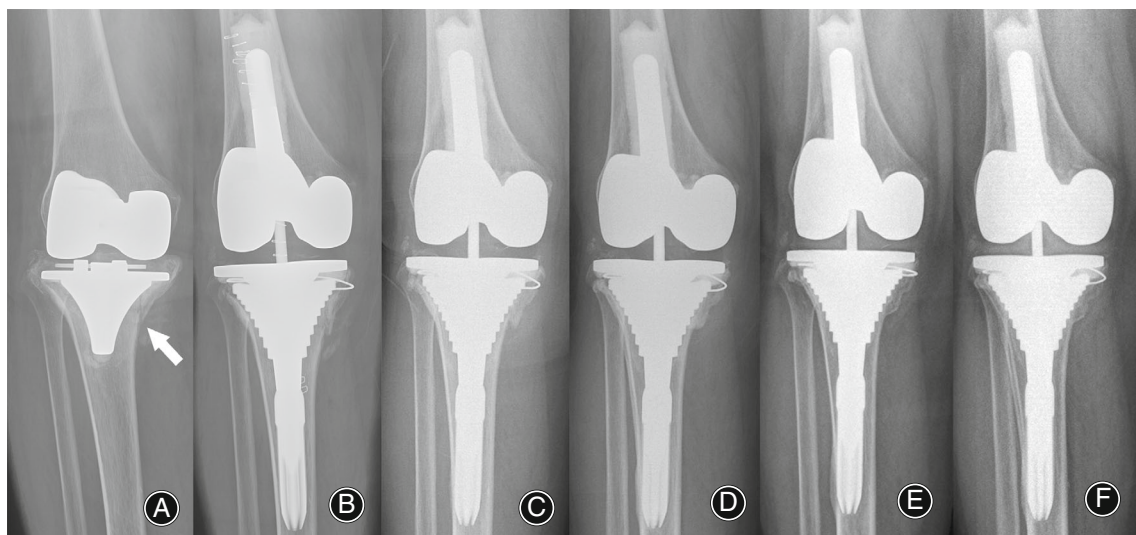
Radiographs of a 78-year-old female who underwent revision TKA with tibial metaphyseal sleeves for aseptic loosening. Preoperative (a) radiograph showed a medial tibial plateau fracture which was treated with wire fixation during surgery (b). From the films of 3 months (c), 6 months (d), and 1 year (e) after surgery, a progressive migration of prostheses was observed. At the final follow-up, stable fixation of the prostheses was achieved and no further migration was found (f). The white arrow refers to preoperative medial tibial plateau fracture
